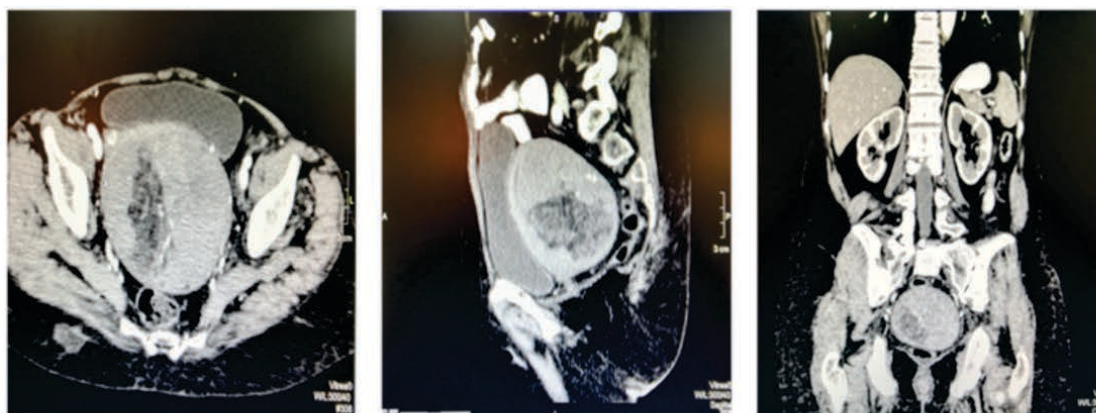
Post Contrast CT Scan Axial and Sagittal Image through Pelvis Showing a Well Marginated Heterogeneously Enhancing Solid Mass with Central Fatty Component
